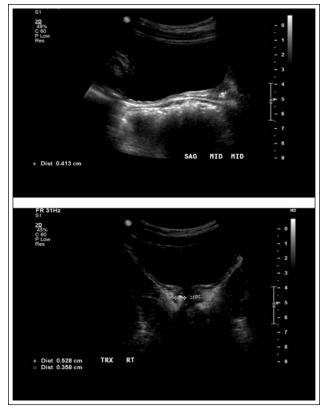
Show different views of bladder ultrasound for Case three which clearly shows the prostatic calculi between markers.
